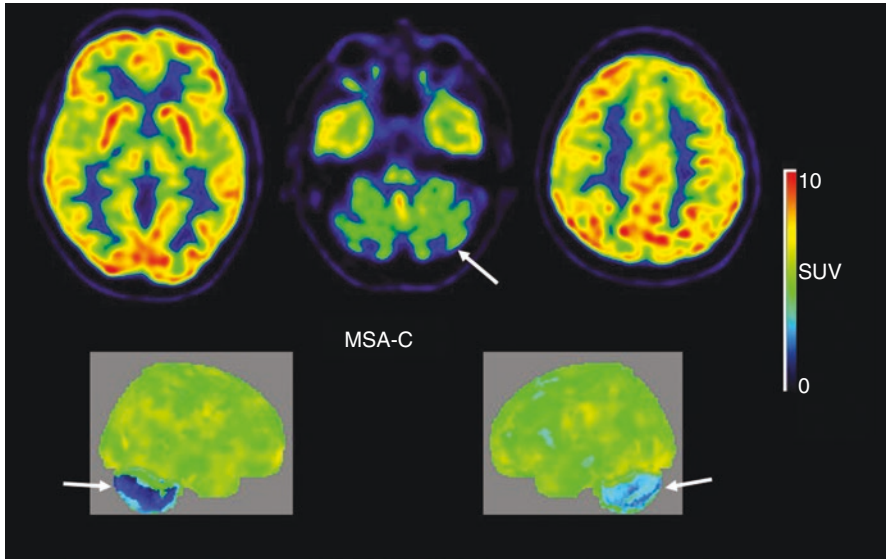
FDG-PET images from a representative case of MSA-C. Decrease metabolism can be observed in the cerebellum (arrows). Courtesy of Dr. Irina Savitcheva, Department of Nuclear Medicine, Karolinska Huddinge University Hospital
